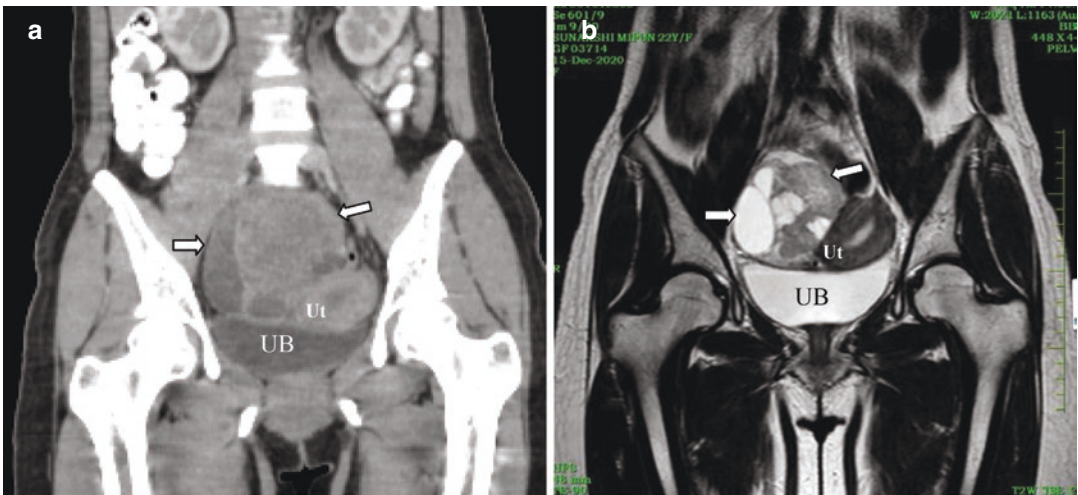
Ovarian cancer. (a, b) Coronal CT scan and T2W MR images showing a solid cystic right adnexal mass (arrows) compressing and displacing the uterus towards left. The details of the pelvic organs and the right adnexal mass are more clearly visualized on MRI (Ut uterus, UB urinary bladder)
